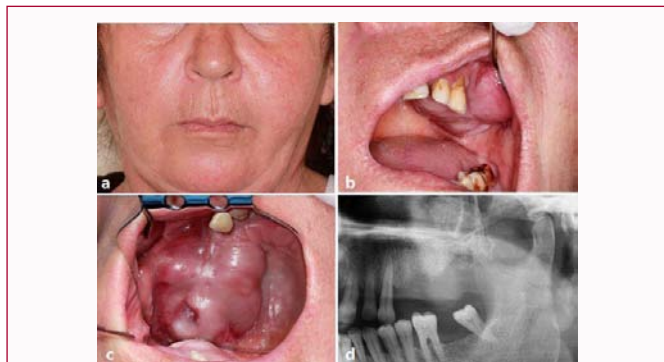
Preoperative Images of Case: a) Extra oral view of swelling in the left quadrant of the maxilla. b,c) Intraoral view of significant expansion in the left maxilla bucco-palatinally, d) Decrease in trabecular structure of the left maxilla on panoramic radiograph.
